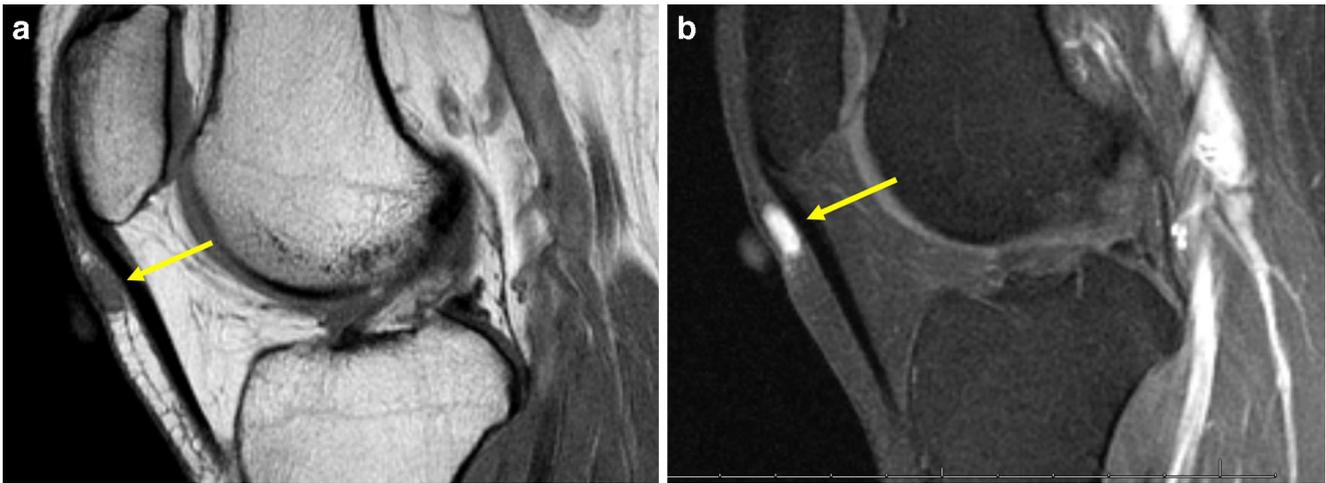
A 32-year-old woman with a palpable non-tender knee mass. a Sagittal proton density-weighted MR image shows a 1.2-cm isointense subcutaneous nodule (*arrow*) in the prepatellar soft tissues. b Sagittal
